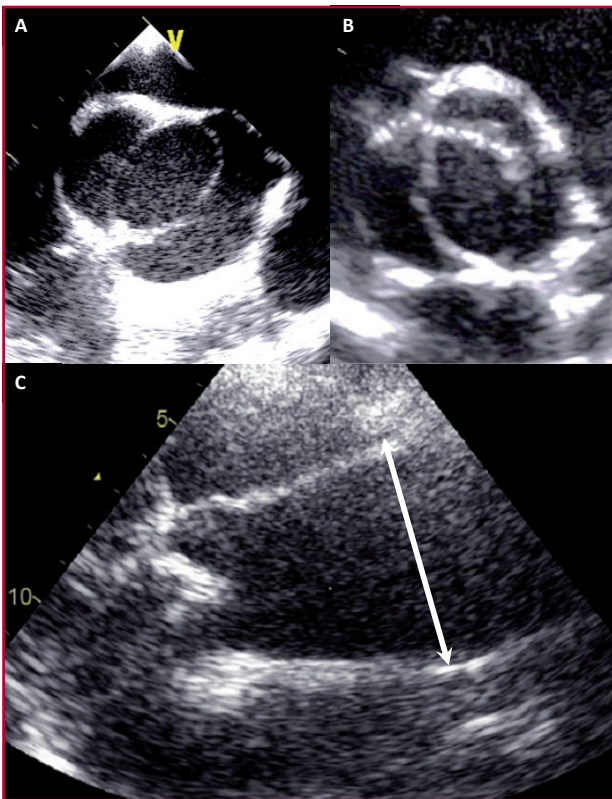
A: Transesophageal echocardiography showing BAV with fusion of right and left coronary cusps. B: TTE showing BAV with right and non-coronary cusp fusion. C: TTE showing dilatation of the tubular aorta.
